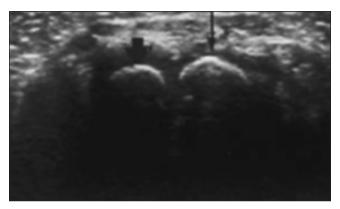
Ultrasonographic view of secondary ossification centers of wrist (arrows)
